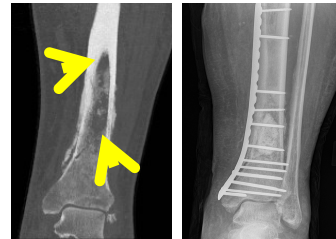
Sagittal CT image through the tibia demonstrates a lytic destructive epiphyseal and diaphyseal distal tibial diaphysis with pathological fracture of the anterior cortex and aggressive mixed periosteal reaction and subtle extension to the distal tibial articular surface.
